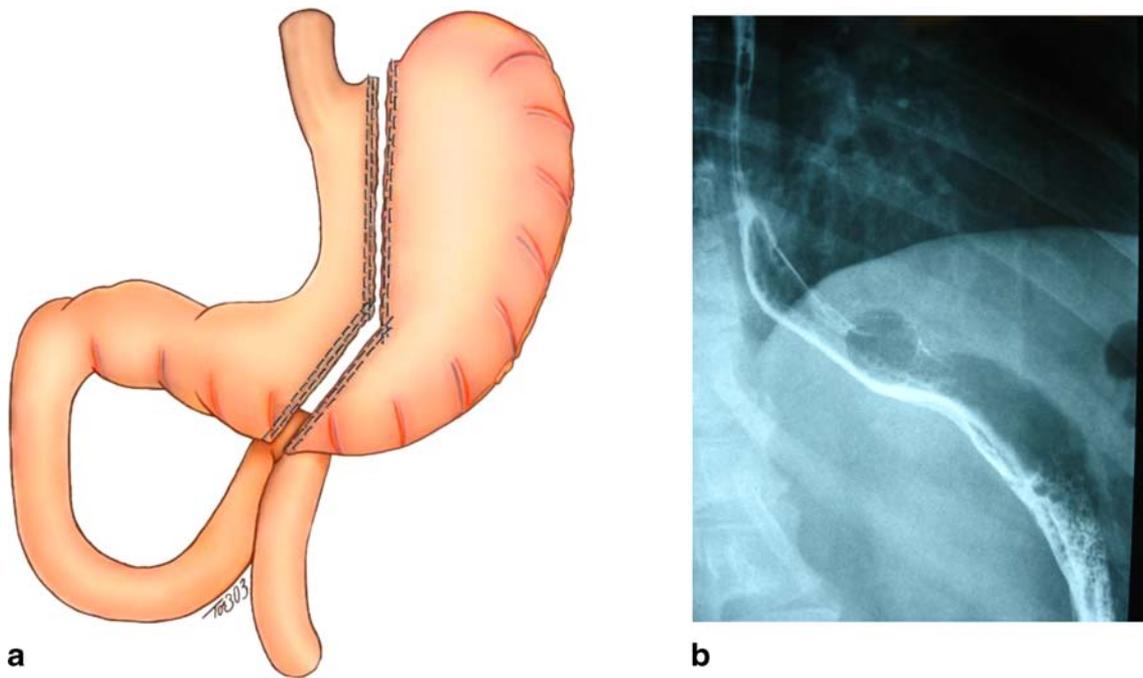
a Scheme for sleeve gastrectomy, performed with a laparoscopic linear cutting stapler, showing also the removed part. b Radiographic aspect postoperatively
